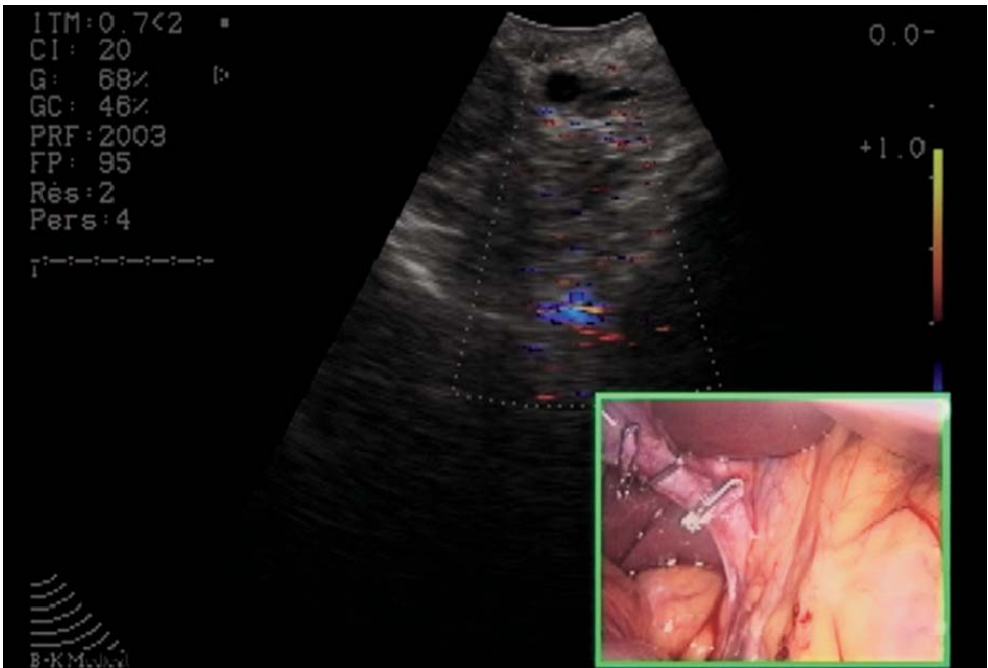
Laparoscopic ultrasound
